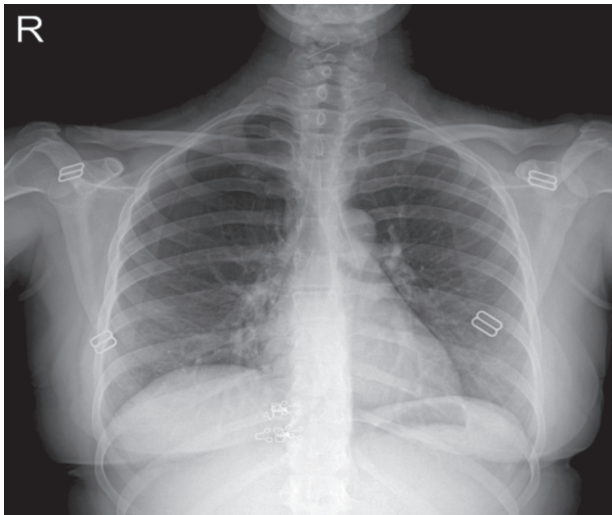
Posteroanterior chest X-ray obtained on admission showing a clear visceral pleural line and a radiolucent area on the right side, consistent with pneumothorax.
